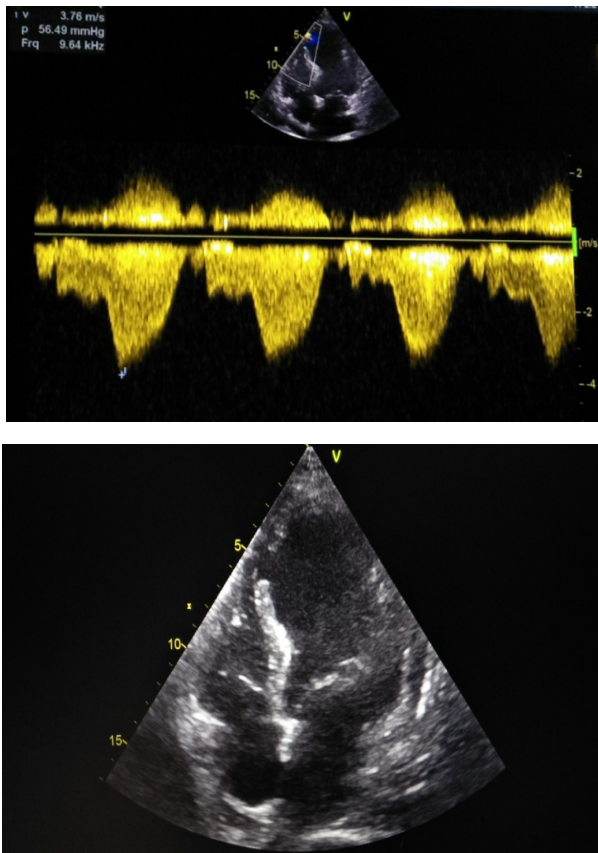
appearance of the ventricular septal defect in two-dimensional and continuous Doppler flow
